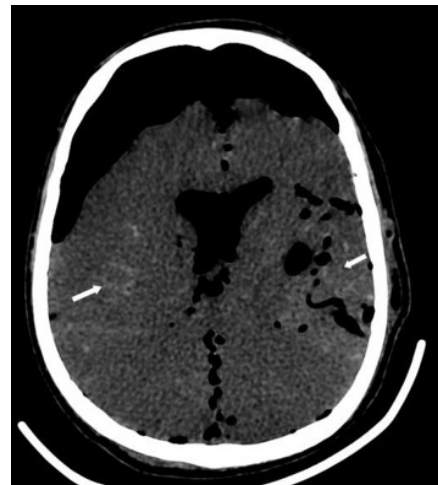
Plain CT brain demonstrates bilateral pseudosubarachnoid signs (white arrow) with loss of grey white matter differentiation in hypoxic ischaemic encephalopathy and massive pneumocephalus.
